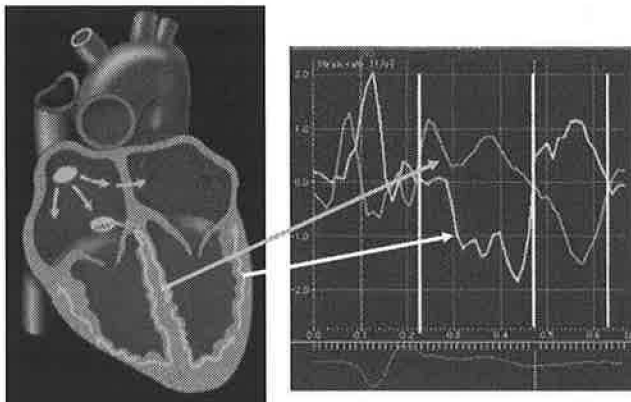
Tissue Doppler imaging comparing septal to lateral contraction velocity. Note the delay in lateral activation until after closure of the aortic valve (middle white line). From Sogaard.
